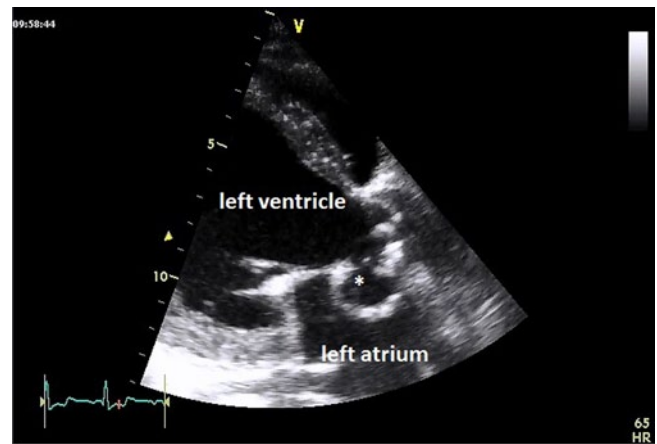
▲ Parasternal long-axis view of a pseudoaneurysm (asterisk)
